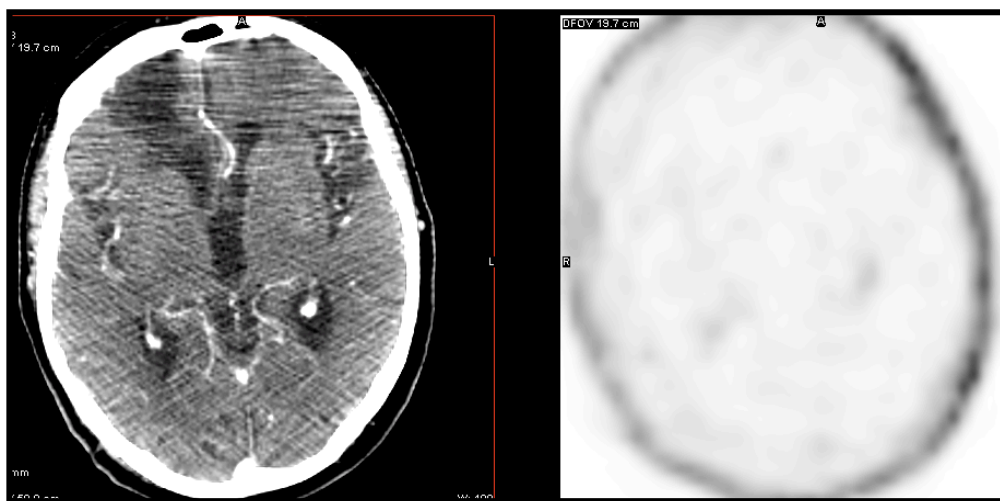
Contrast-enhanced CT and PET with ^{18}F -methylcholine in a patient with right-sided frontal lobe encephalomalacia as a sequela of a previous infarct. Physiological lack of avidity in the brain parenchyma makes it challenging to exclude such anatomical abnormalities. This is evident in the CT image and very difficult to appreciate on the PET only image.
